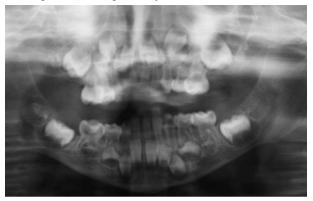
Panoramic radiograph of Case No. 4 at the age of four years and six months showing the double tooth on the right side of the mandible and the congenitally missing permanent mandibular left central incisor.
